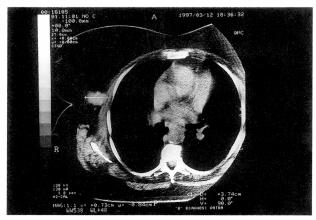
CT scan showing a tumor (maximum diameter: 3.74 cm) along the right anterior axillary line.
